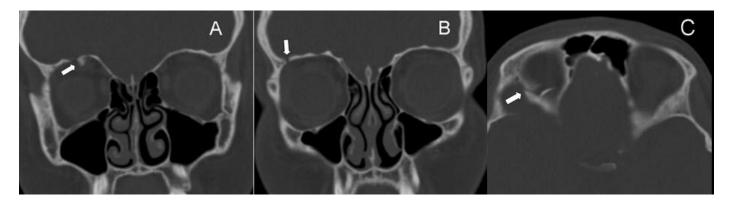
13-year-old male with comminuted right orbital roof "blow-in" fracture. Four day follow-up unenhanced CT orbits (obtained with a Siemens SOMATOM® Definition AS 128-slice CT scanner, Siemens Healthcare, using bone algorithm; axial acquisition of 0.6 mm thickness over the area scanned with subsequent reconstruction into 2 mm contiguous axial scans of 2 mm thickness; bone window settings; 120 kV; 210 mAs; Total Dose: 330 mGy) coronal reformation images demonstrate (a) stable right orbital roof "blow-in" fracture with fragment involvement of the superior rectus muscle (arrow) and (b) stable extension of orbital roof fracture without supraorbital rim involvement (arrow). Axial image demonstrates (c) stable extension of right orbital roof fracture (arrow).
